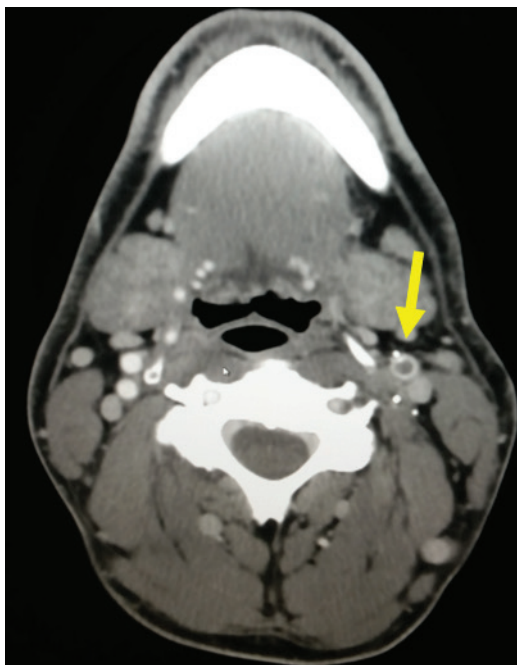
Cervical neck CT with angiogram. Note the complete occlusion of the left internal carotid (white arrow) with adjacent metallic fragments, consistent with a penetrating injury.
